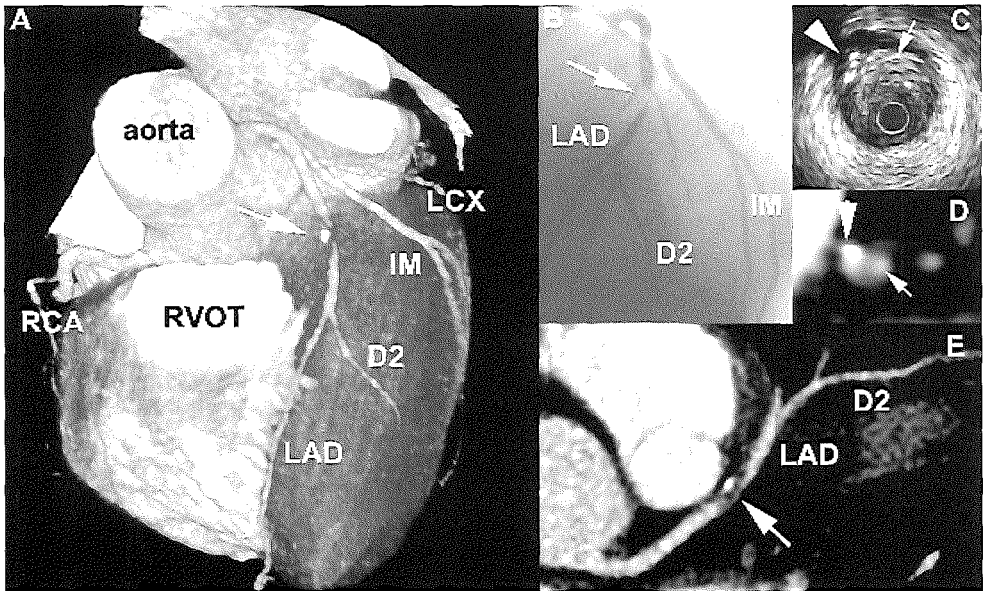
Multislice computed tomography (MSCT) angiogram of an obstructed left anterior coronary artery (LAD) and a heart rate of 49 beats/min. A significant stenosis (arrow) can be observed in the LAD. The three dimensional volume rendered overview (A) shows the lesion just distal to a small diagonal branch, which is confirmed by conventional angiography (B). The cross sectional (D) and longitudinal reconstructions (E) show a partially calcified lesion, which is confirmed by intracoronary ultrasound (C). D2, second diagonal branch; IM, intermediate branch; LCX, left circumflex coronary artery; RCA, right coronary artery. RVOT, right ventricular outflow tract.
